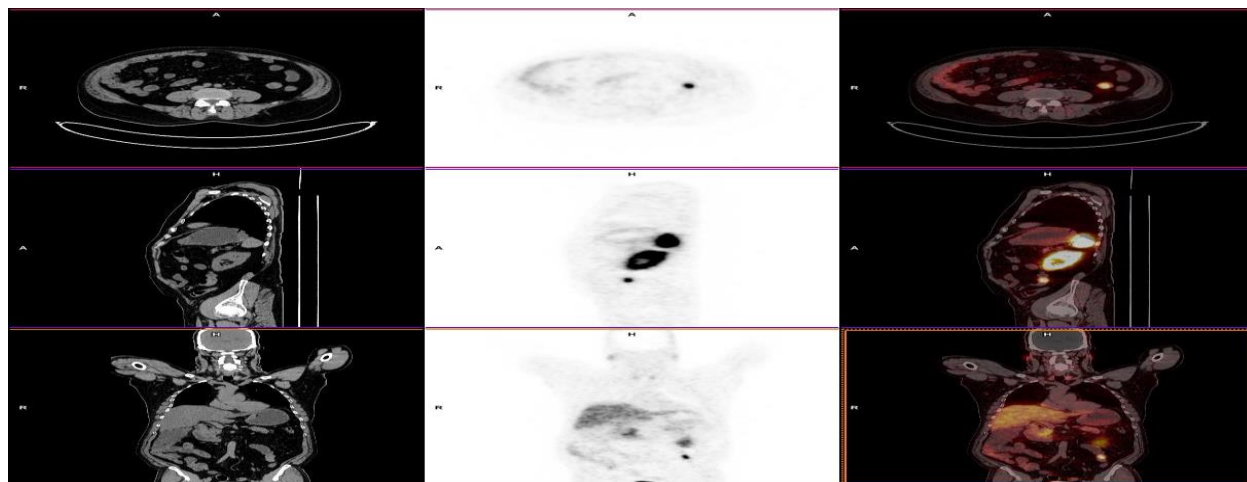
CT image (A,D,G), MIP image (B,E,H) and corresponding axial fused image (C,F,I) of a case showing ileal NET; on biopsy. Intense DOTANOC avid ileal lesion in MIP and fused with no obvious morphological abnormality on corresponding CT scan.
